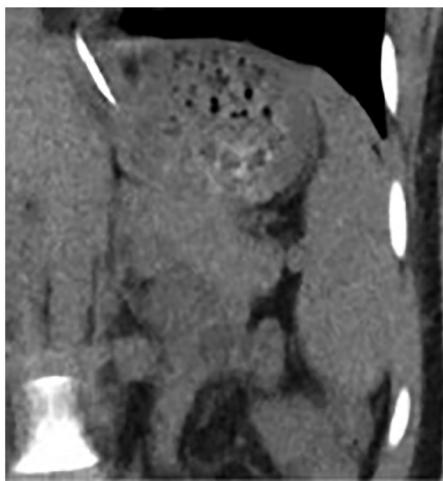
Computed tomography of the abdomen performed 24 h after overdose in patient 5.
